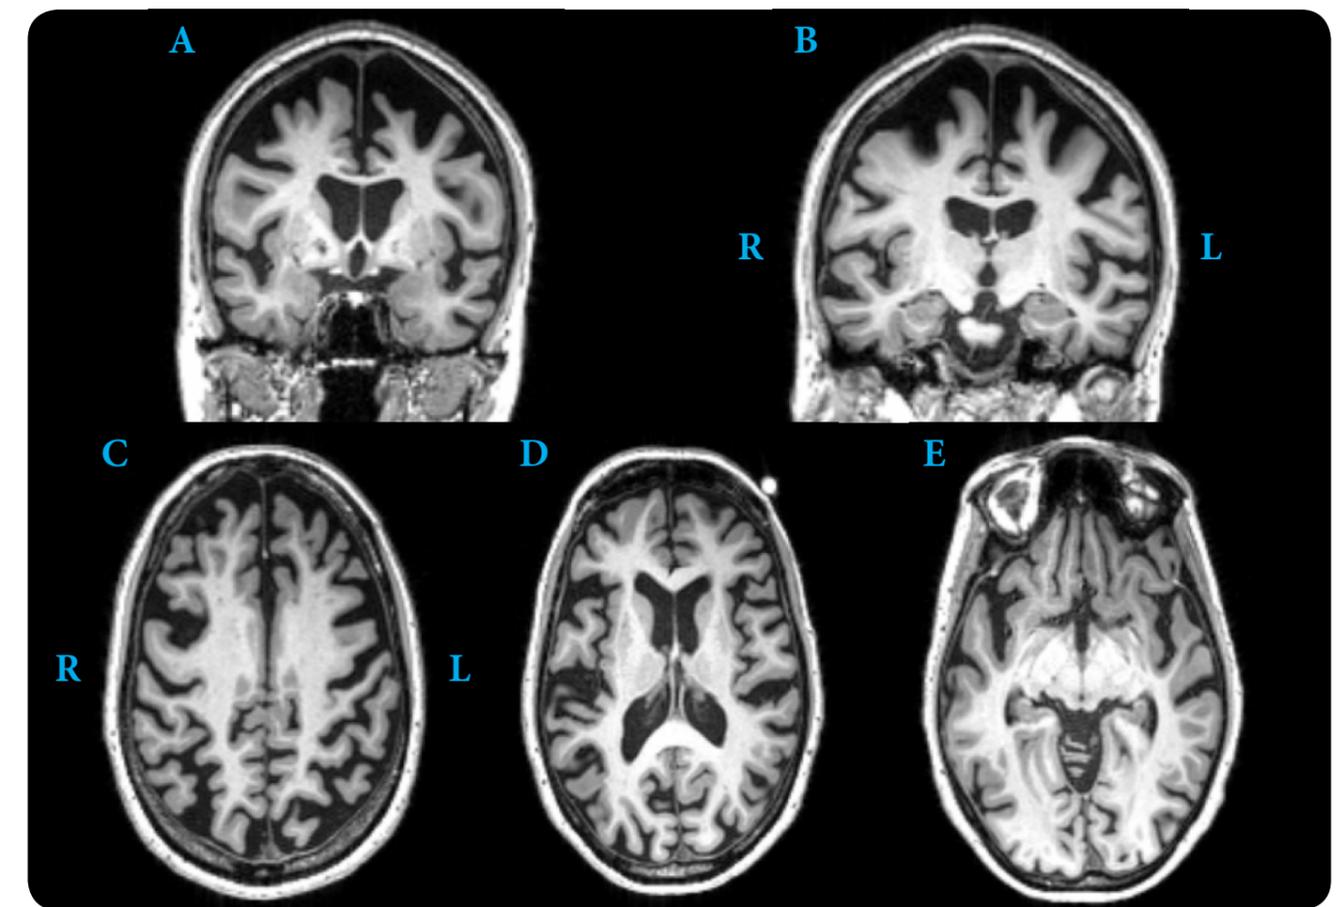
Case 1 brain MRI of Mr. X showing atrophy in the coronal plane (A, B) and axial plane (C, D, E)
